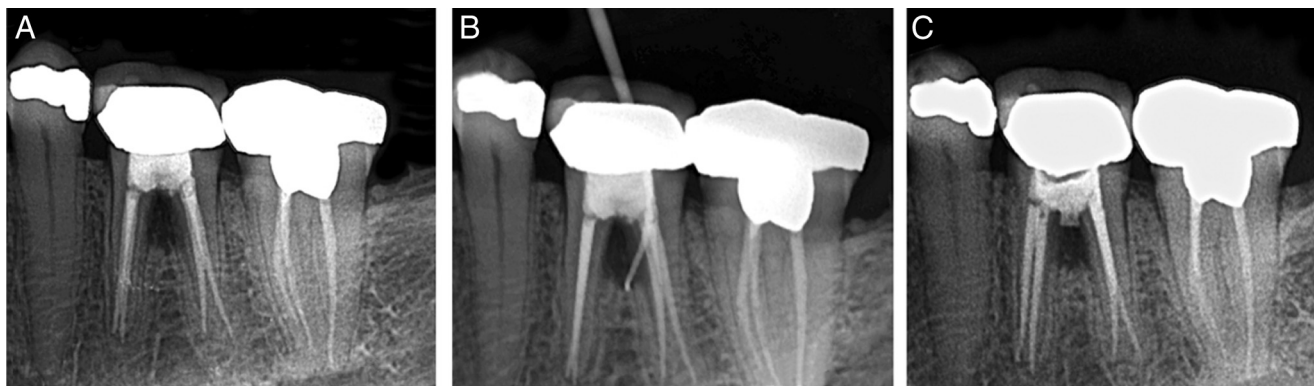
(A) A preoperative radiograph showing radiolucency associated with the furcation of tooth #19. (B) A radiograph with gutta-percha point placed in gingival sulcus sinus tract. (C) Pre-existing MTA removed and replaced with fresh and well-adapted MTA.
